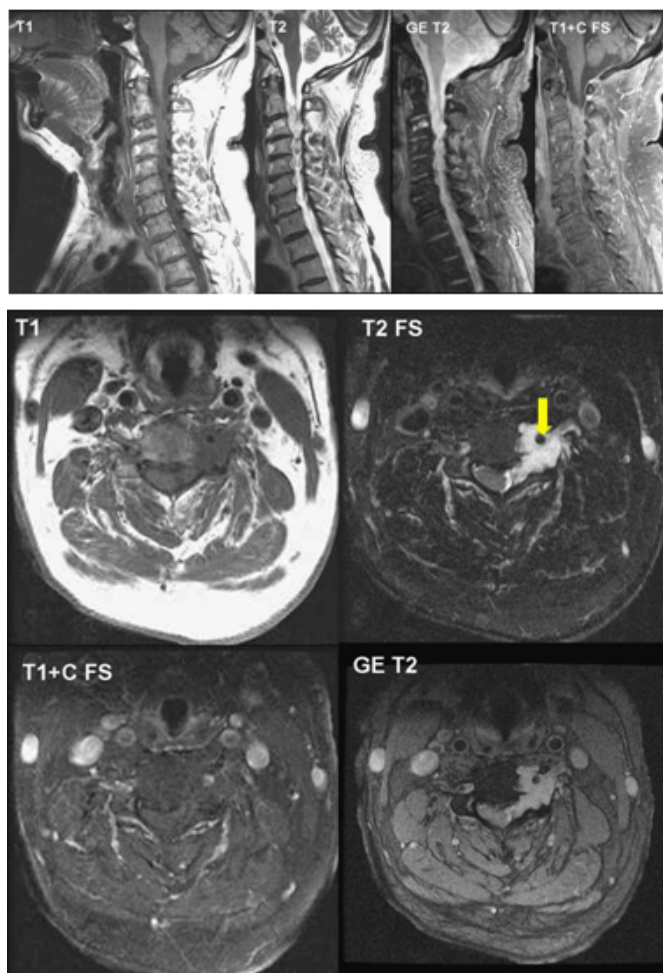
Preoperative C-spine MRI scan. (A) sagittal view, (B) Axial view demonstrating a mildly enhancing mass lesion hyperintensity in T2-weighted image involving the left side spinal canal and the left neuroforamina from C2 to C6 with erosion of adjacent vertebral body and encasement of the left vertebral artery (yellow arrow) and significant cord compression at the level of C3.
